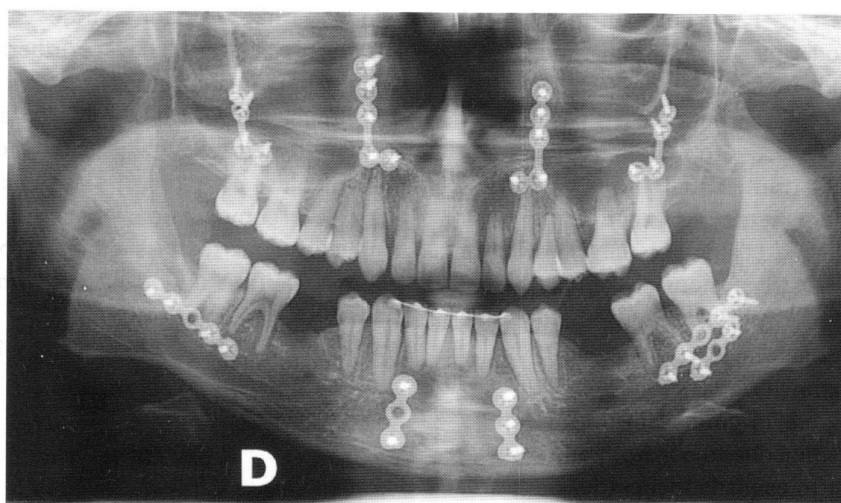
Radiographic image after the orthognatic surgery for a second skeletal class.
